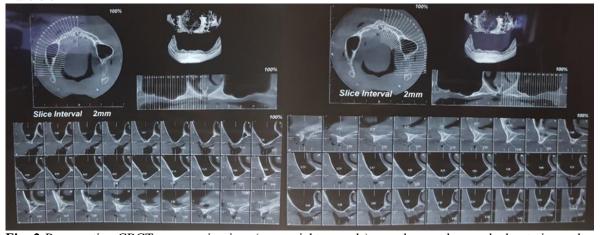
Preoperative CBCT, panoramic view (upper rights panels) reveal severely resorbed anterior and posterior maxillary bone (Right& Left), axial view (upper lefts panels) show two highly pneumatized sinuses and narrow
